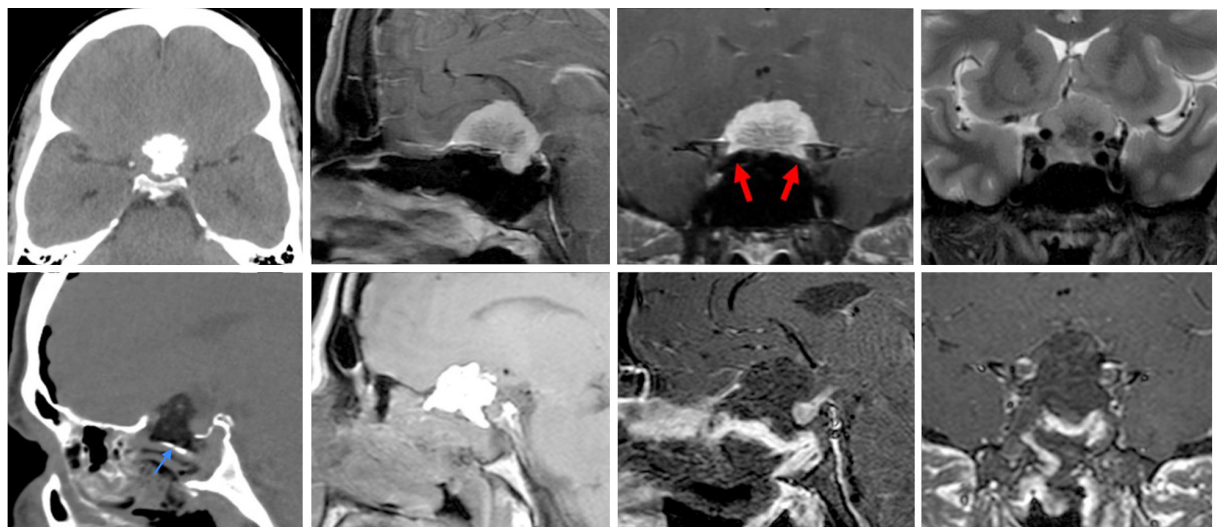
A 39-year-old man presented with progressive left eye vision loss over several months. Pre-operative imaging demonstrates a large, calcified tuberculum sellae/planum meningioma with extension into the sella. Bilateral optic canal invasion is seen, left more than right (red arrows). The left internal carotid artery is encased, with significant encroachment upon the right carotid artery. An endoscopic transtuberculum/transplanum approach was performed without complication. Post-operative MRI demonstrates gross total resection. A fat graft is in the resection cavity with a well-vascularized nasoseptal flap over a bony buttress (posterior nasal septum graft; blue arrow). The pituitary gland and infundibulum enhance normally.
